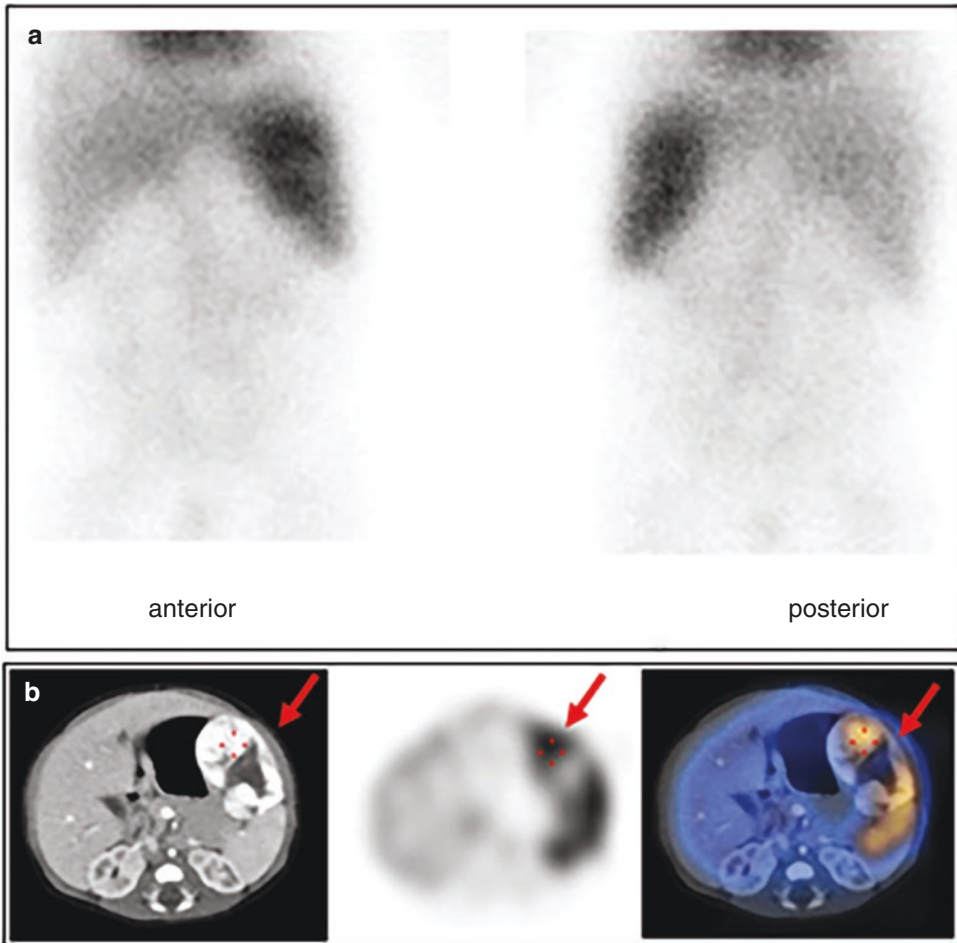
History: A newborn in whom prenatal US detected a large mass in the left lobe of the liver confirmed on postnatal US was referred for RBCs scan since a hepatic hemangioma was included in the differential diagnosis. Study report: Late anterior and posterior planar images (a) show high physiologic activity in the splenic blood pool. A previously performed contrast-enhanced (ce) CT (b, left image) shows an enhancing mass (arrow) in the left hepatic lobe displacing the spleen posteriorly. SPECT (b, middle image) and co-registered SPECT-ceCT
